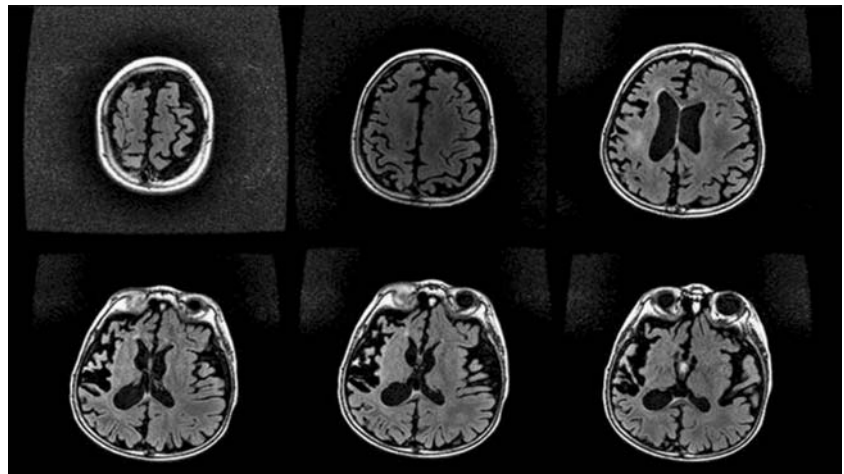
T2 FLAIR MRI of brain at age of 4 years showed more severe atrophic change in right hemisphere, especially the right middle temporal and insular area. The previous hyperintense lesion over right parietal area could not be found anymore
